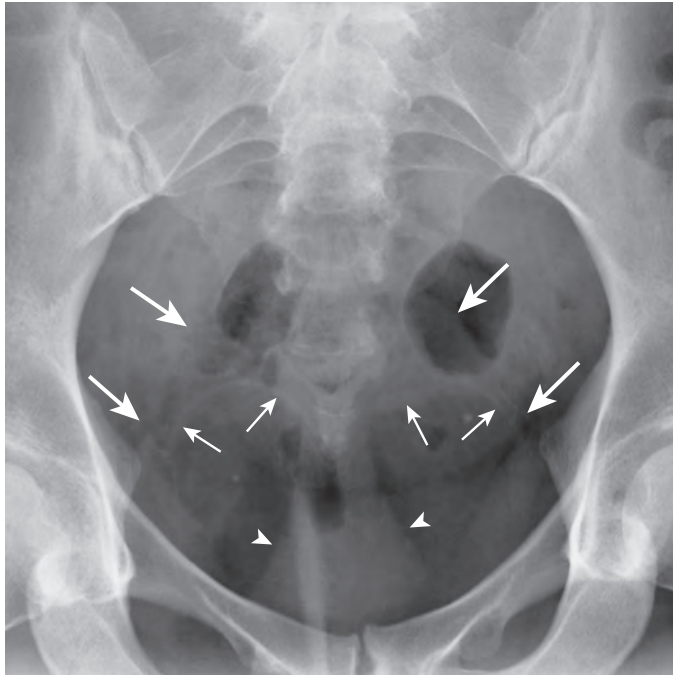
Piriformis muscle. Coned-down view of the pelvis from a supine abdominal radiograph shows the inferior margins of the piriformis muscles bilaterally (large arrows). Inferior to the piriformis muscles is the edge of the sacrospinous ligament and associated coccygeus muscles (small arrows) outlining the roof of the ischiorectal fossa. The perineum forms the medial boundary of the ischiorectal fossa (arrowheads).
